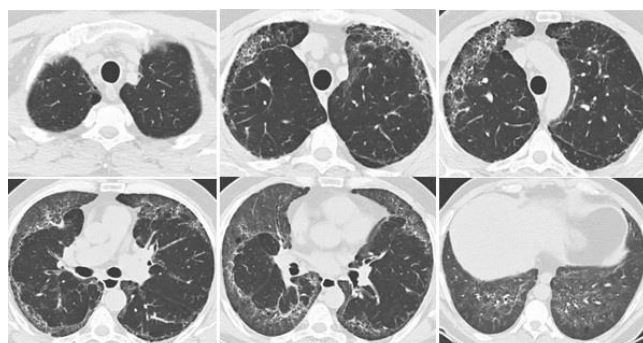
HRCT revealing bilateral peripheral subpleural interlobular septal thickening and ground-glass attenuation without the apices involvement and ground-glass attenuation on the basales
